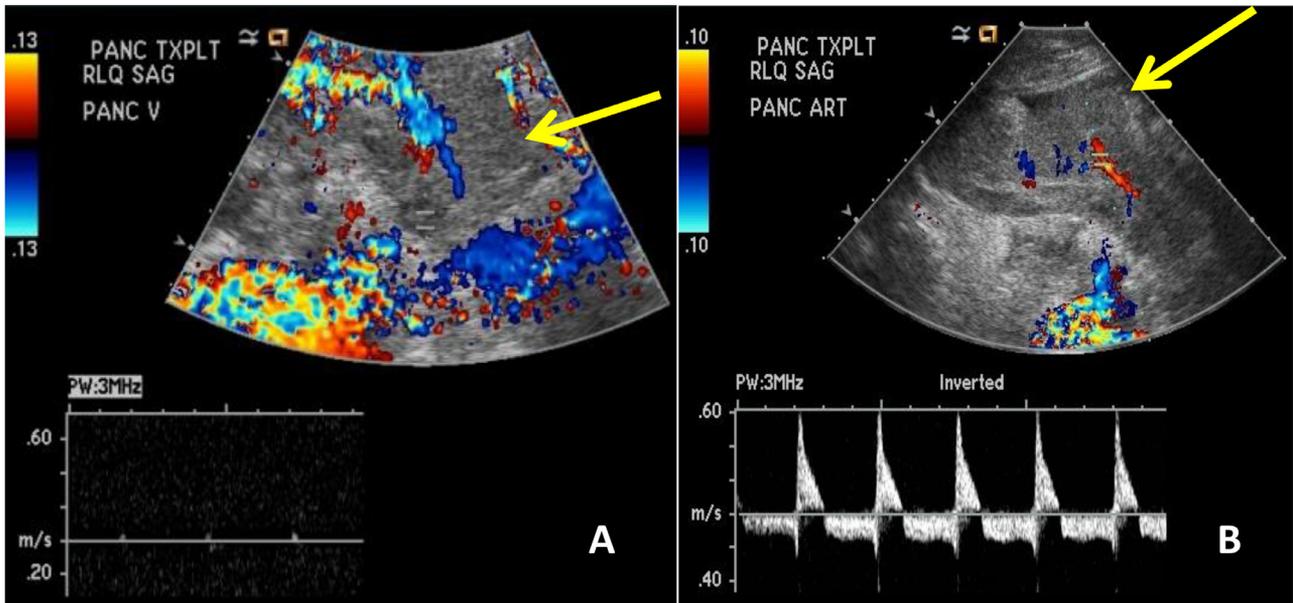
Color Doppler US images of the transplanted pancreas in a 44-year-old female demonstrate absent wave form in the pancreatic vein (Image A), reversal of diastolic flow of the pancreatic artery (Image B), and heterogeneous echotexture of the pancreas (arrow). These findings are consistent with pancreatic vein thrombosis.
